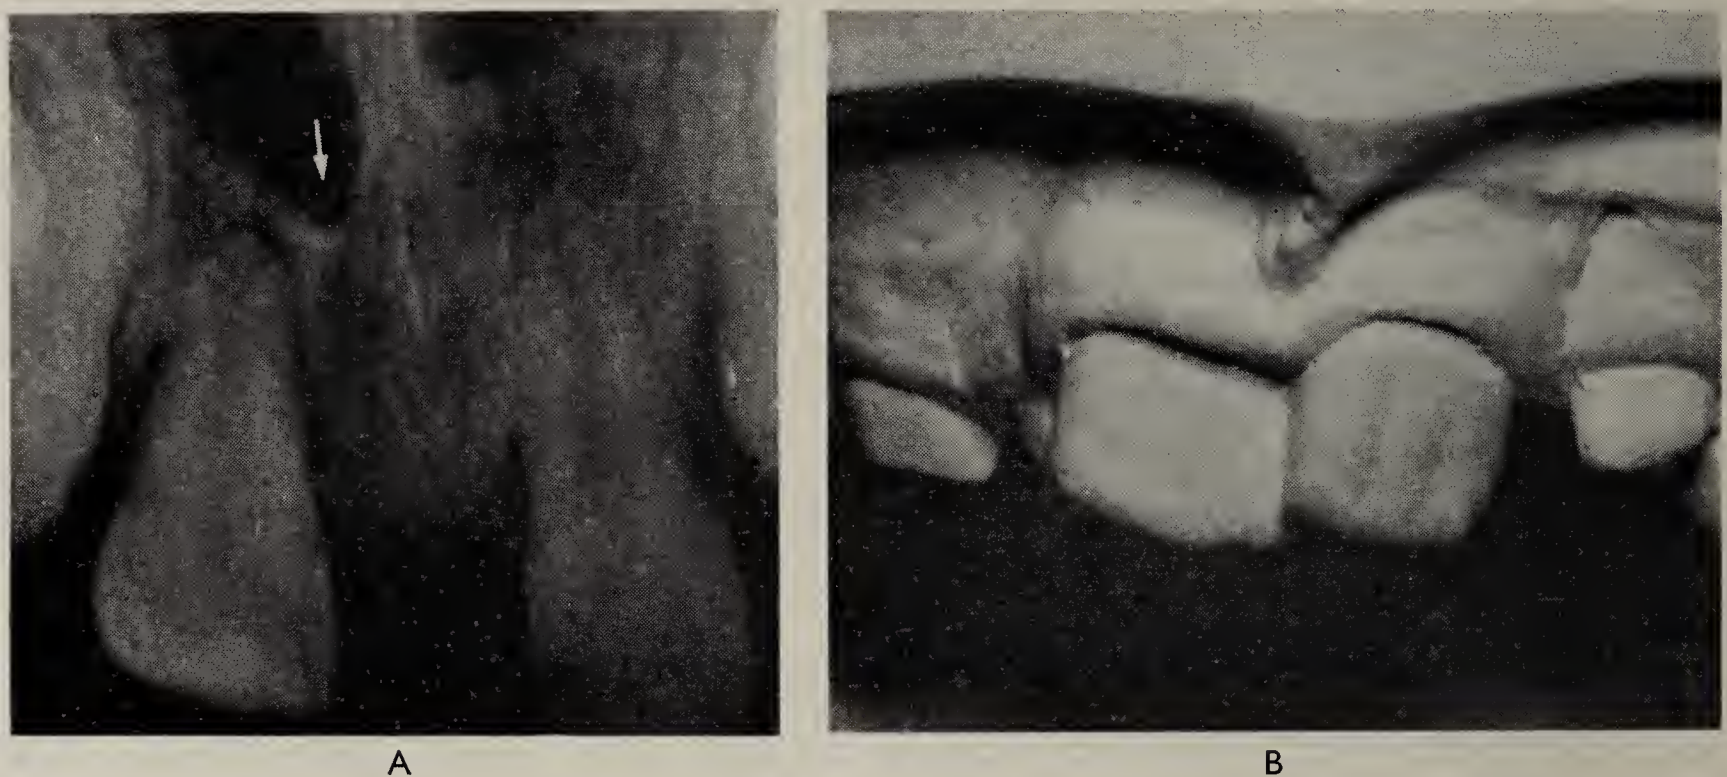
Microforms associated with lip clefts. A, Intra-oral radiograph of patient with unilateral lip cleft on right side showing defect in nasal floor. B, Model of patient with bilateral lip cleft and cleft palate with alveolar defects.
